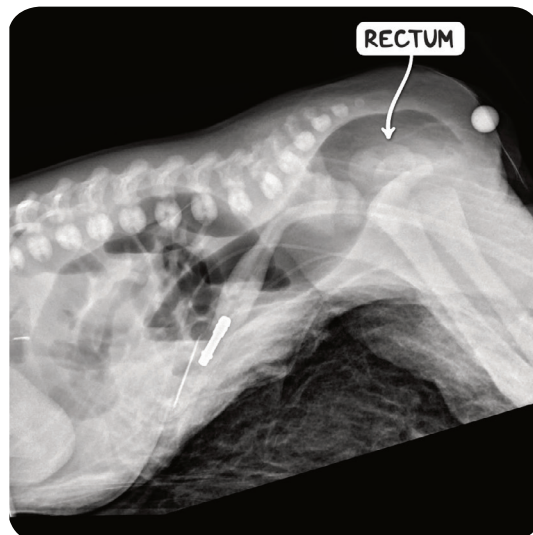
A lateral X-ray of a neonate demonstrating an imperforate anus. The rectum is dilated and the anal canal is absent.
